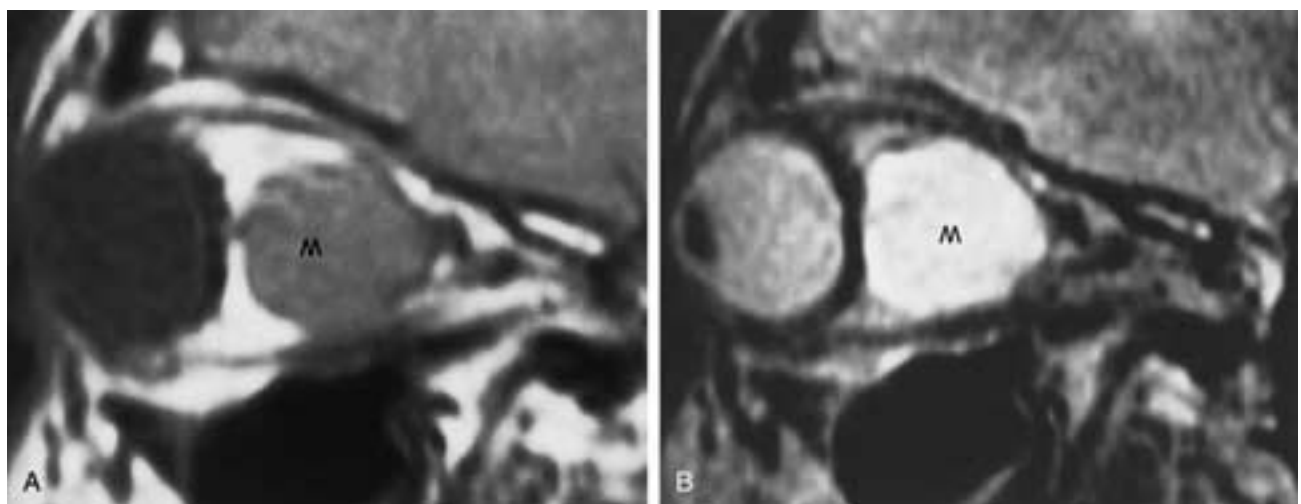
Cavernous hemangioma. A, Sagittal PW MR scan. B, Sagittal T2-weighted MR scan. Scans show an intraconal mass (*M*), which was presumed to be a cavernous hemangioma.
